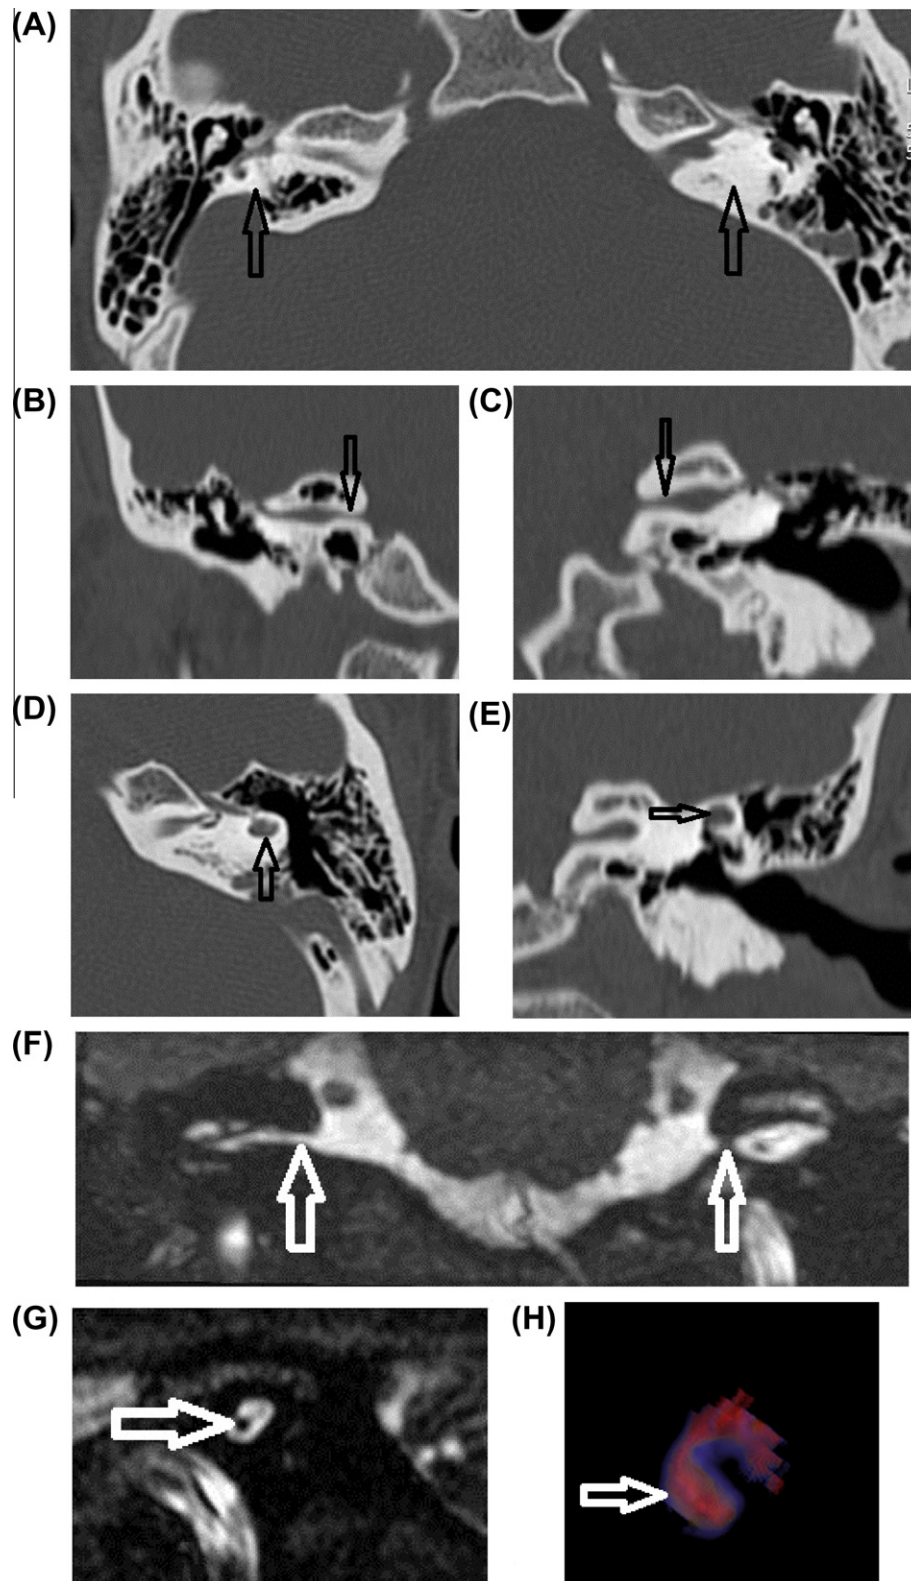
A case of right sided A1–6 D0 N1 and left sided A1,3–6 D2 N1 anomalies (Michel deformity). A axial CT image showed absent labyrinth in both sides (arrows). (B and C) Coronal CT images showed stenotic (aplastic) internal auditory canals (IAC) bilaterally. (D and E) Axial and coronal CT images showed dysplastic rudimentary bud at the anatomical site of the left vestibule (arrows), also shown in H (VR image). F (axial) and G (sagittal oblique) thin MRI images (FIESTA) showed absent cochlear nerve while only facial nerve is present within the IAC (arrow in G).
